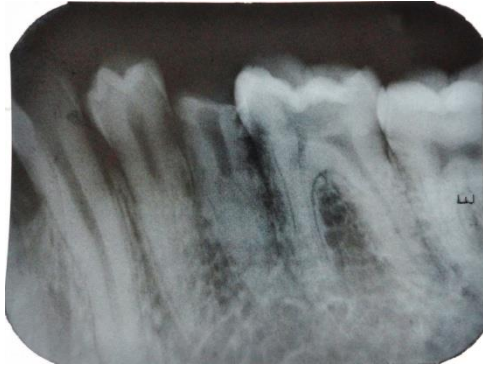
Preoperative radiograph shows a wide pulp canal space till the middle third of the canal followed by a sudden thinning.
